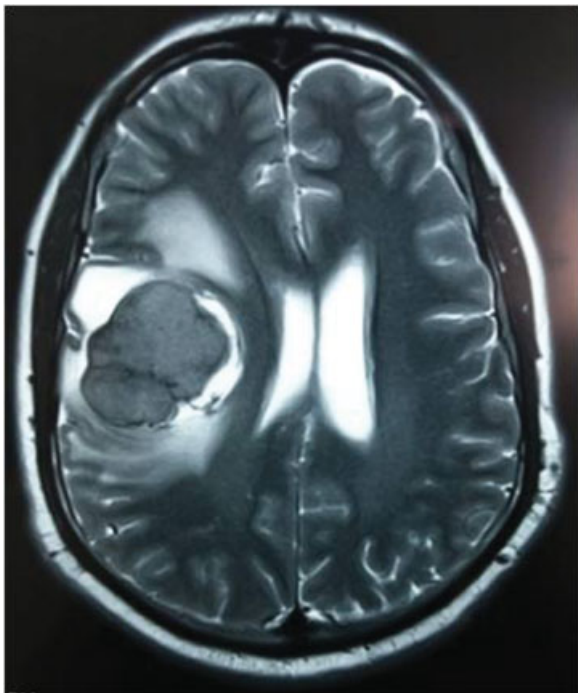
Axial T2-weighted axial image reveals an iso-hypointense mass with marked peritumoral edema.
